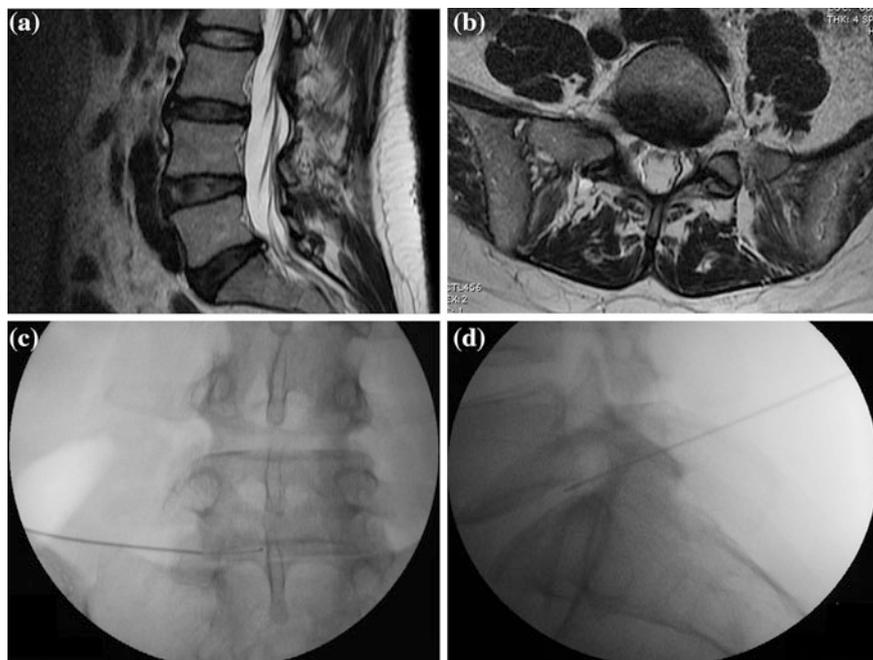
Case #2 a High-intensity zone at the posterior annulus of L5-S1 consistent with annular tear, sagittal T2 MRI. b Mild broad-based left-sided L5-S1 disc protrusion, axial T2 MRI. c AP view of #25 inner needle curving out of #21 outer needle and into the left posterior annulus of L5-S1. d Lateral view of C, in position for PRP injection
